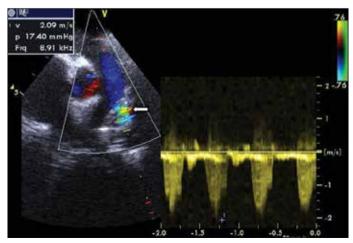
Postoperative transthoracic echocardiographic parasternal short axis view shows mild left pulmonary artery stenosis at the level of anastomosis line (arrow)
